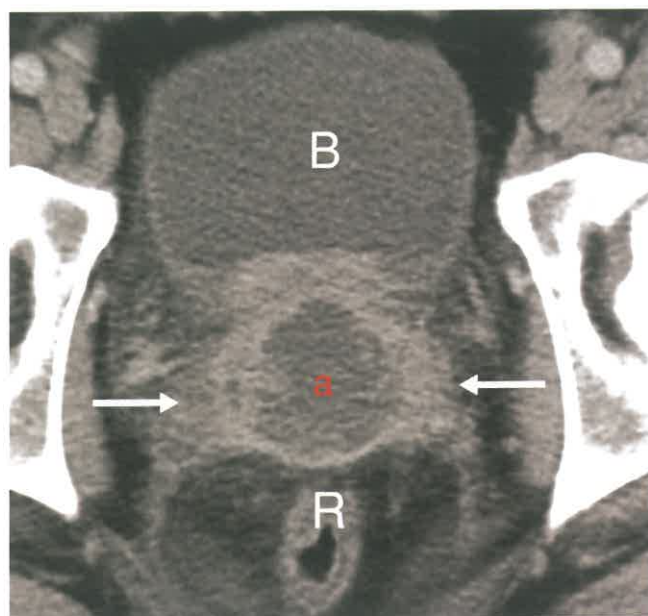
Prostate Abscess. Axial postcontrast CT shows a large irregular fluid collection (a) replacing and expanding most of the prostate gland representing an abscess. Periprostatic tissues (arrows) are infiltrated and edematous reflecting inflammation. B, bladder; R, rectum.
